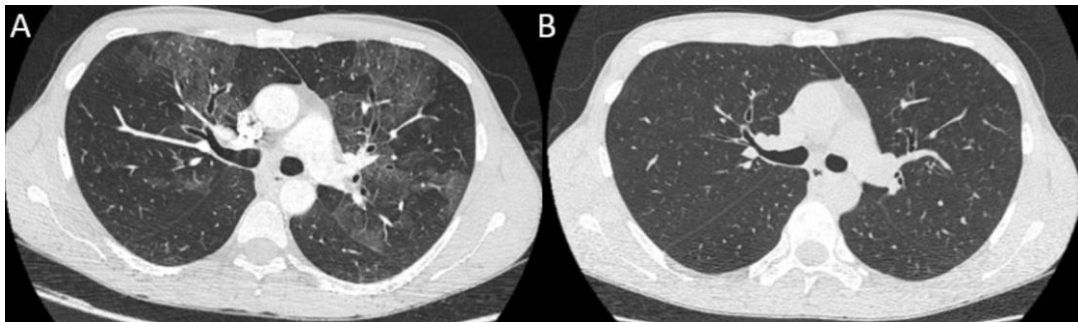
CT chest imaging
